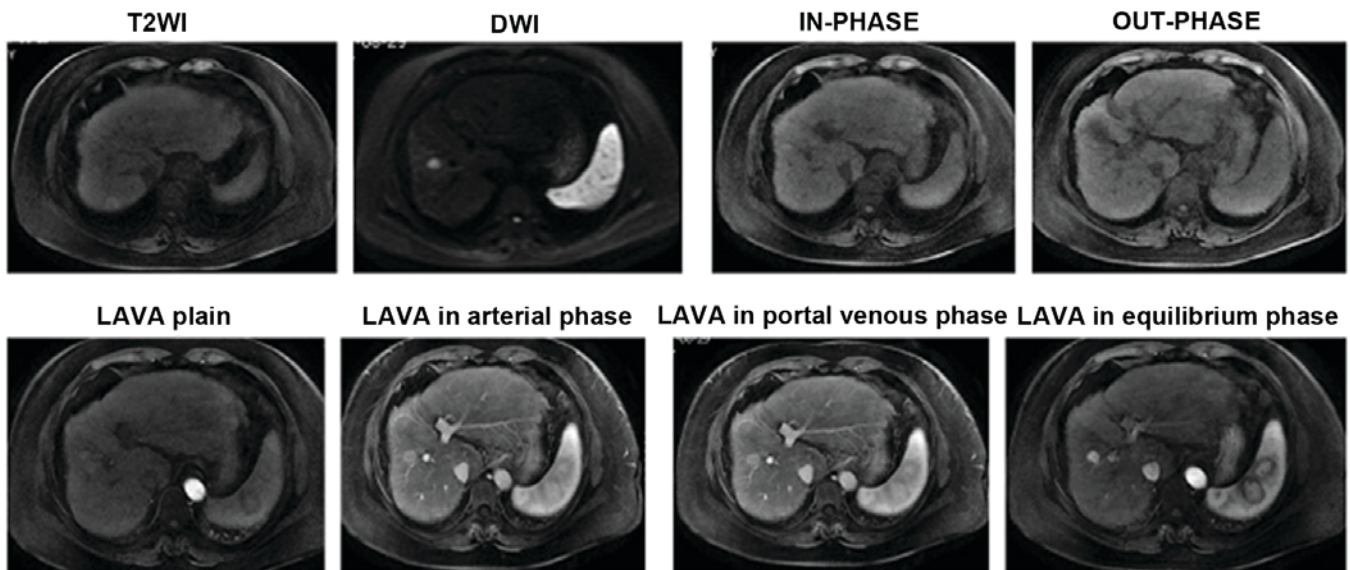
MRI examination of T2WI, DWI, IN-PHASE, OUT-PHASE, LAVA plain scan, and LAVA in arterial phase, portal venous phase, and equilibrium phase. MRI, magnetic resonance imaging; DWI, diffusion weighted imaging; T2WI, T2 weighted imaging; LAVA, liver acquisition with volume acquisition.
